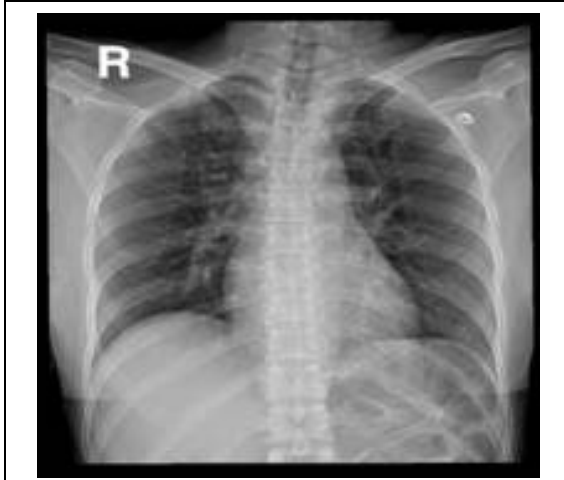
X-ray of the chest of the study patient
